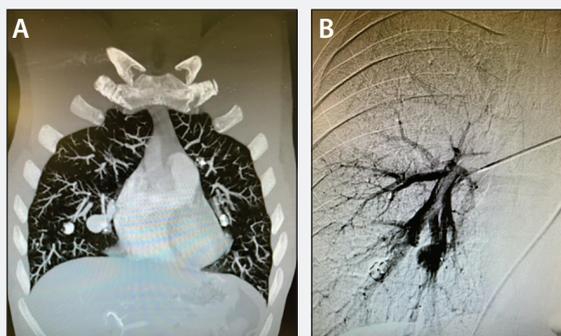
CTA revealed multiple PAVMs (A). Selective angiography of the right inferior lobe PAVM (B).
